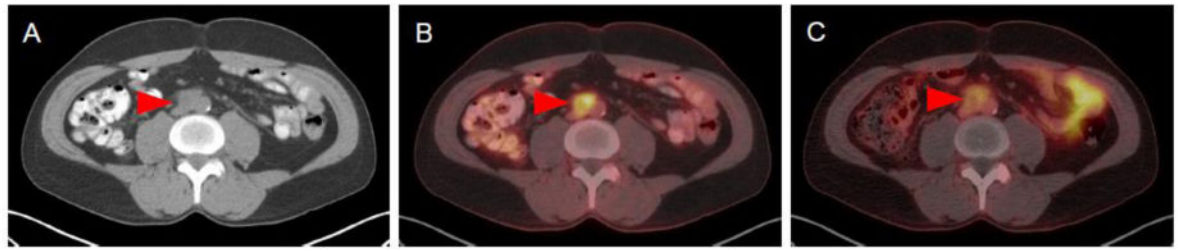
Imaging findings of Patient 3. (A) The patient had a 2.2 cm retroperitoneal portocaval lymph node on contrast-enhanced CT. (B) This lesions was avid for ^{18}F -FDG ($\text{SUV}_{\text{max}} = 5.7$) and (C) to a lesser extent ^{18}F -DCFPyL ($\text{SUV}_{\text{max}} = 3.1$).
